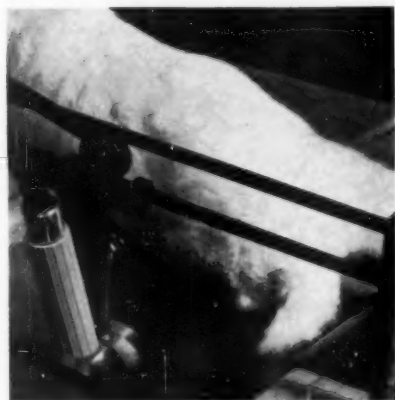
An unanesthetized rabbit held in position by straps with the left knee area immersed directly in the path of the ultrasonic energy from the moving transducer.
